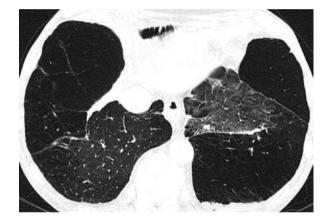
HRCT of the lungs: paraseptal, bullous emphysema in combination with centrilobular emphysema
